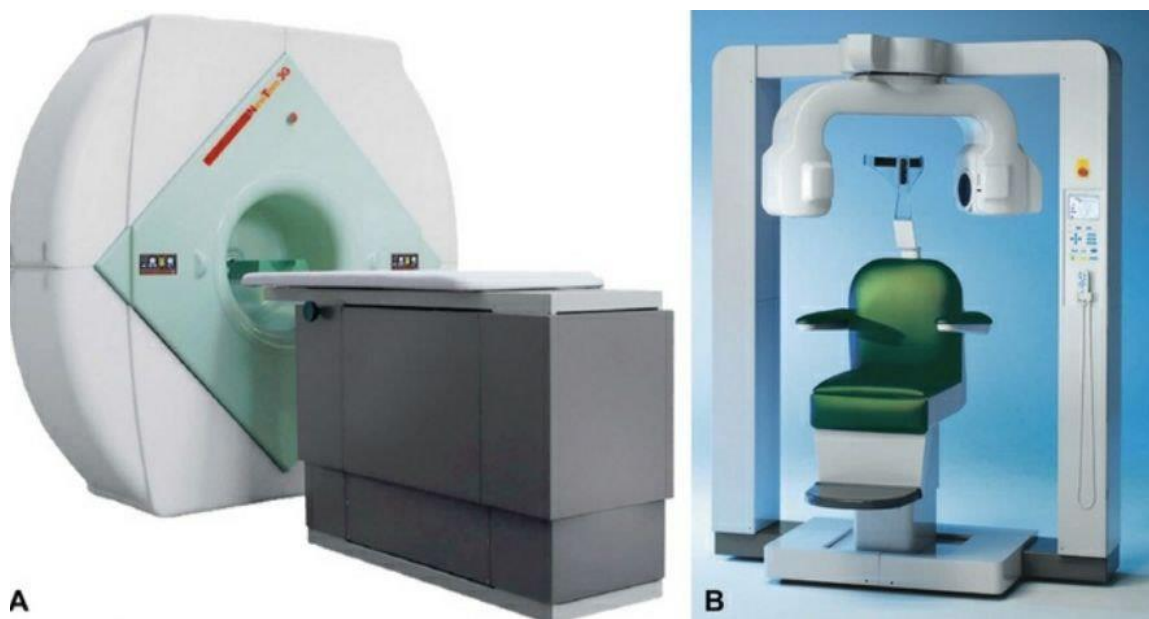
The first commercially available maxillofacial cone beam computed tomography units in the United States. (A) Supine type. (B) Seated type (Mallya and Lam, 2018).
